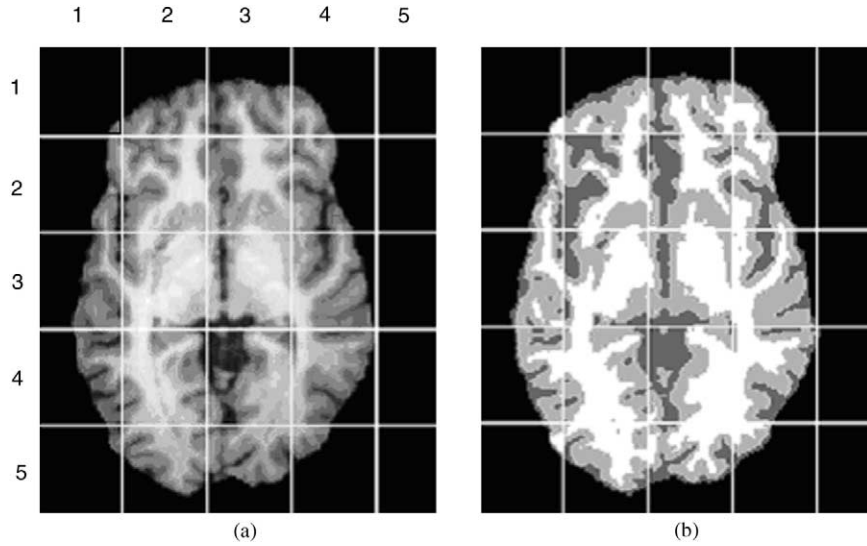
MGFC hard segmentation: (a) Original T1-weighted image. (b) MGFC segmentation.
